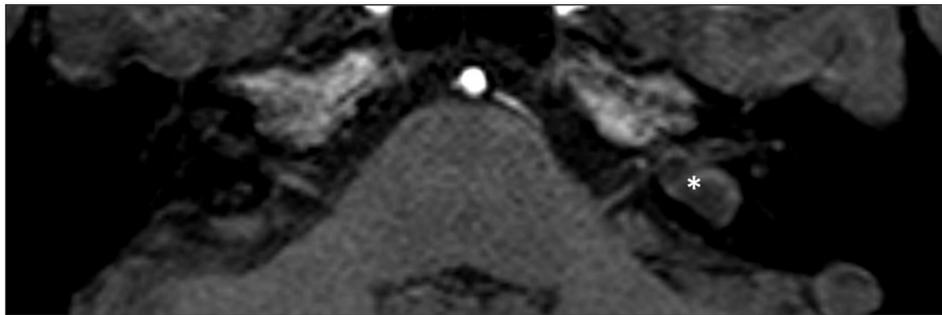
Axial hi-resolution T1-weighted sequence (T1W-3D FFE) at the level of the internal auditory canal. Note isodense soft tissue structure (white asterisk) within protrusion, appearing to be an upward extension of the jugular bulb
